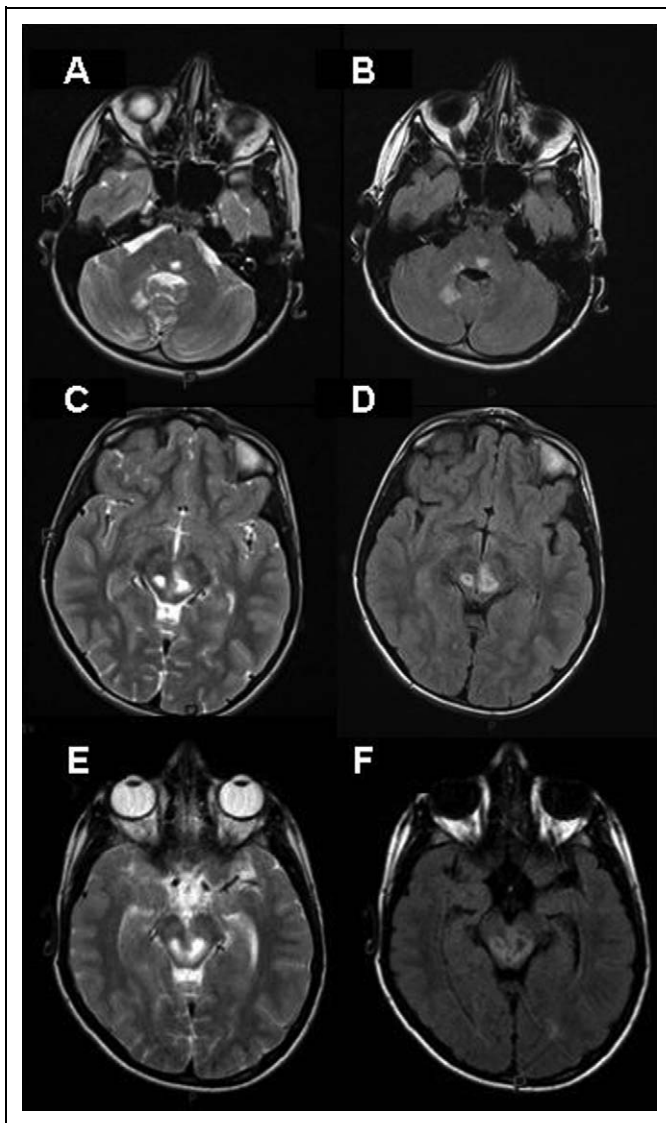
Serial magnetic resonance imaging (MRI). Axial T2-weighted (A, C, E) and axial T2-weighted fluid attenuated inversion recovery sequences (B, D, F) show an increased bilateral signal in the brainstem involving the tegmentum mesencephali, periaqueductal region, and, at left, the red nucleus, posterior, and paramedian region of the pons, as well as the paramedian region of medulla oblongata. Lesions are also visible in the superior and middle right cerebellar peduncles and right dentate nucleus. Central hypointense signal on fluid attenuated inversion recovery sequences corresponds to necrotizing lesions with cavitation. Four months later, brain magnetic resonance imaging showed an increase in lesion size (E, F).
